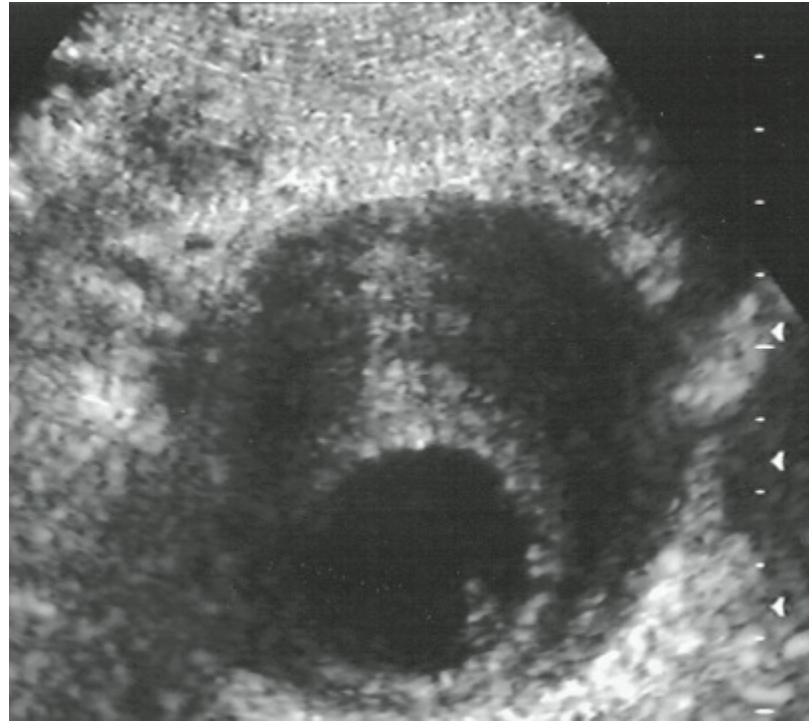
B-mode ultrasound image showing a transverse view of an infrarenal abdominal aortic aneurysm. Note the vessel wall and the large quantity of intraluminal clot surrounding the smaller, blood-filled center (*dark circle*).
